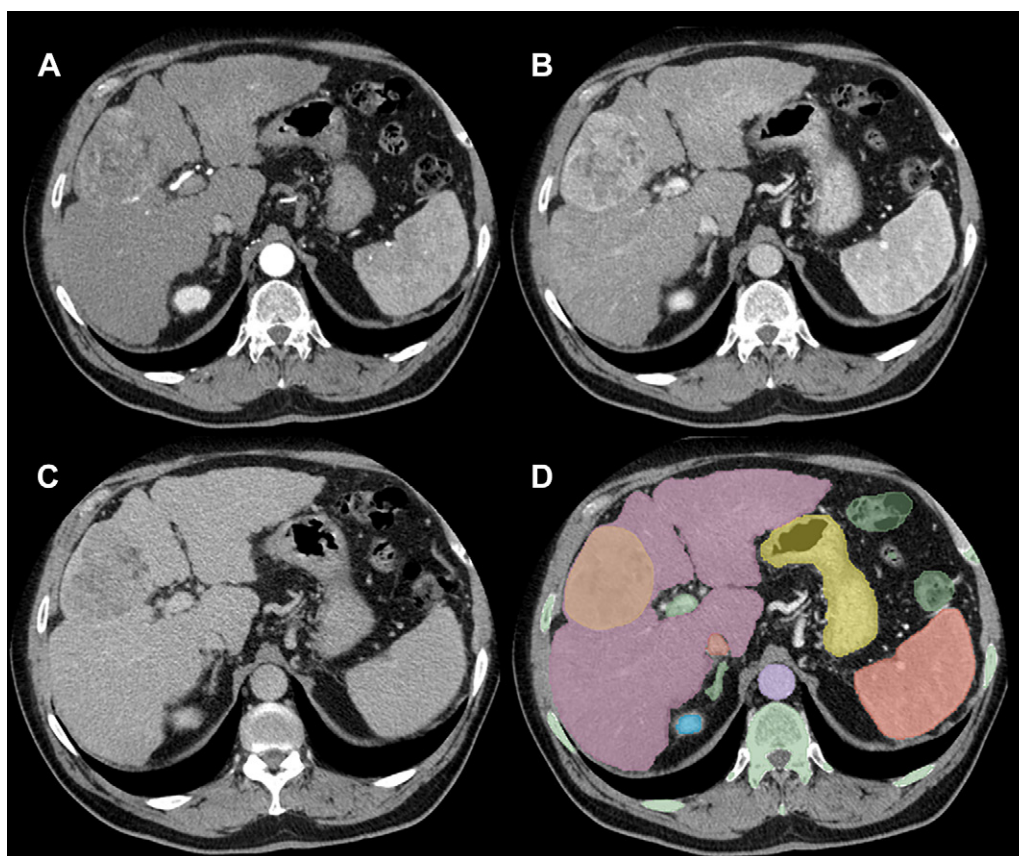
Visual representations of sample axial contrast-enhanced CT images and segmentations: (A) arterial phase, (B) portal venous phase, (C) delayed phase, and (D) segmented tumor with multiple organ masks, respectively.
